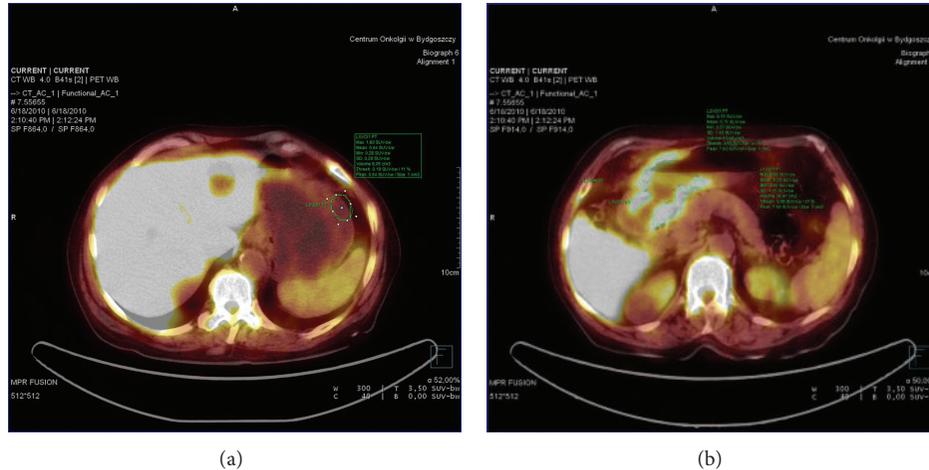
(a)  $^{18}\text{F}$ -FLT-PET in patient with undifferentiated adenocarcinoma.  $\text{SUV}_{\text{max}}$  in normal gastric wall was 1.8. (b)  $^{18}\text{F}$ -FLT-PET in patient with undifferentiated adenocarcinoma.  $\text{SUV}_{\text{max}} = 8.9$ .
